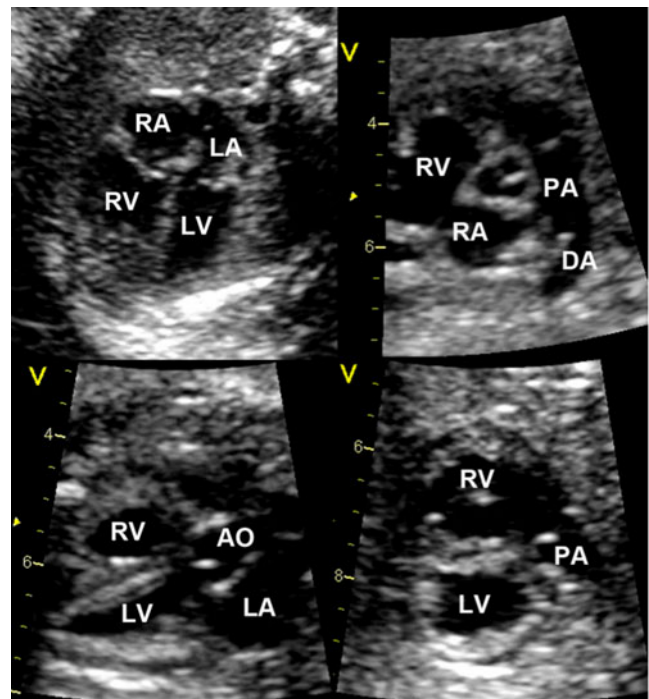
Fetal echocardiogram during the second trimester can clearly show cardiac anatomy and ventricular size. This image depicts a normal 4-chamber view of the heart (top left), short axis (top right), left ventricular outflow tract (bottom left), and right ventricular outflow tract (bottom right)
